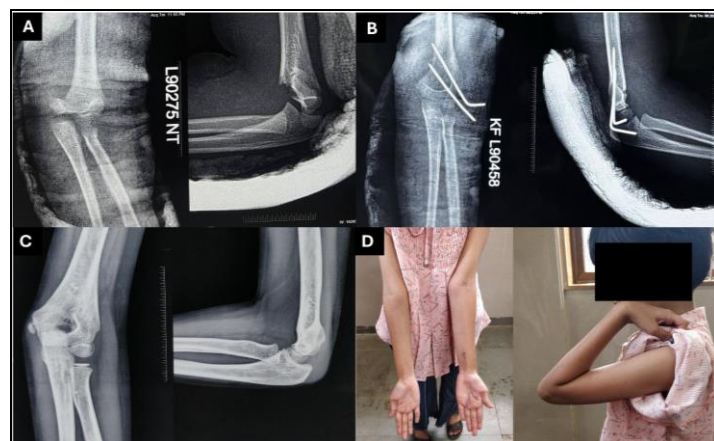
(A) Anteroposterior and lateral radiographs of elbow showing Gartland type 2B supracondylar humerus fracture in 8-year-old girl (B) Immediate post-operative radiograph showing fracture fixed by closed reduction and percutaneous pinning with two lateral K-wires with acceptable reduction (C) Post-operative radiograph at five months follow-up showing complete union (D) Clinically, carrying angle restored compared to opposite side with normal elbow flexion
